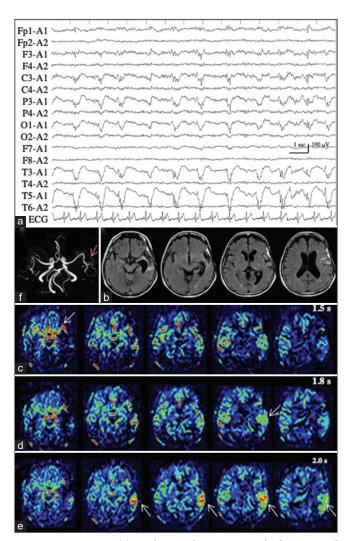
Patient 3. (a) Ictal EEG shows LPD with the maximal amplitude on the posterior temporal region of T5. (b) MR images with fluid attenuated inversion recovery sequence show a surgical defect in the left temporal lobe, with enlargement of the inferior horn. (c-e) PASL images with PLD of 1.5 s (c), 1.8 s (d), and 2.0 s (e) clearly show the hemodynamics of ictal hyperperfusion. At PLD of 1.5 sec, when the ATA of major arteries, particularly left MCA, is prominent (white arrow in (c)), increased ASL signals of the left posterior temporal lobe, the postero-dorsal part of the resection cavity, is not apparent. The ASL signal of the left posterior temporal lobe is slightly increased at PLD of 1.8 s (white arrow in (d)), and apparently increased at PLD of 2.0 s (white arrows in (e)). ATA of major arteries is decreased. (f) MRA reveals the hypervascularity at the periphery of left MCA (red arrow). EEG: Electroencephalogram, LPD: Lateralized periodic discharges, MR: Magnetic resonance, PASL: Pulsed arterial spin labeling, PLD: Post labeling delay, MCA: Middle cerebral artery, ASL: Arterial spin labeling, ATA: Arterial transit artifact, MRA: Magnetic resonance angiography.
